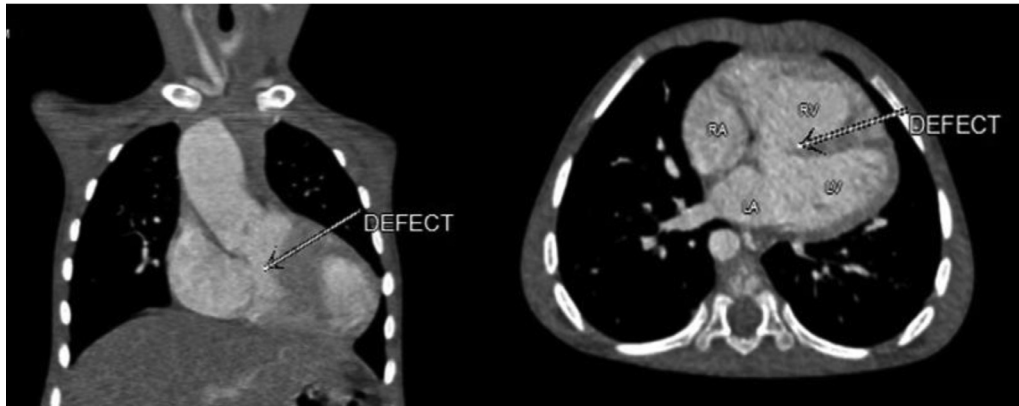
Computed tomography pulmonary angiography (CTPA), coronal and axial sections reveal a defect that connects the right ventricle and left ventricle which is a VSD (ventricular septal defect).
